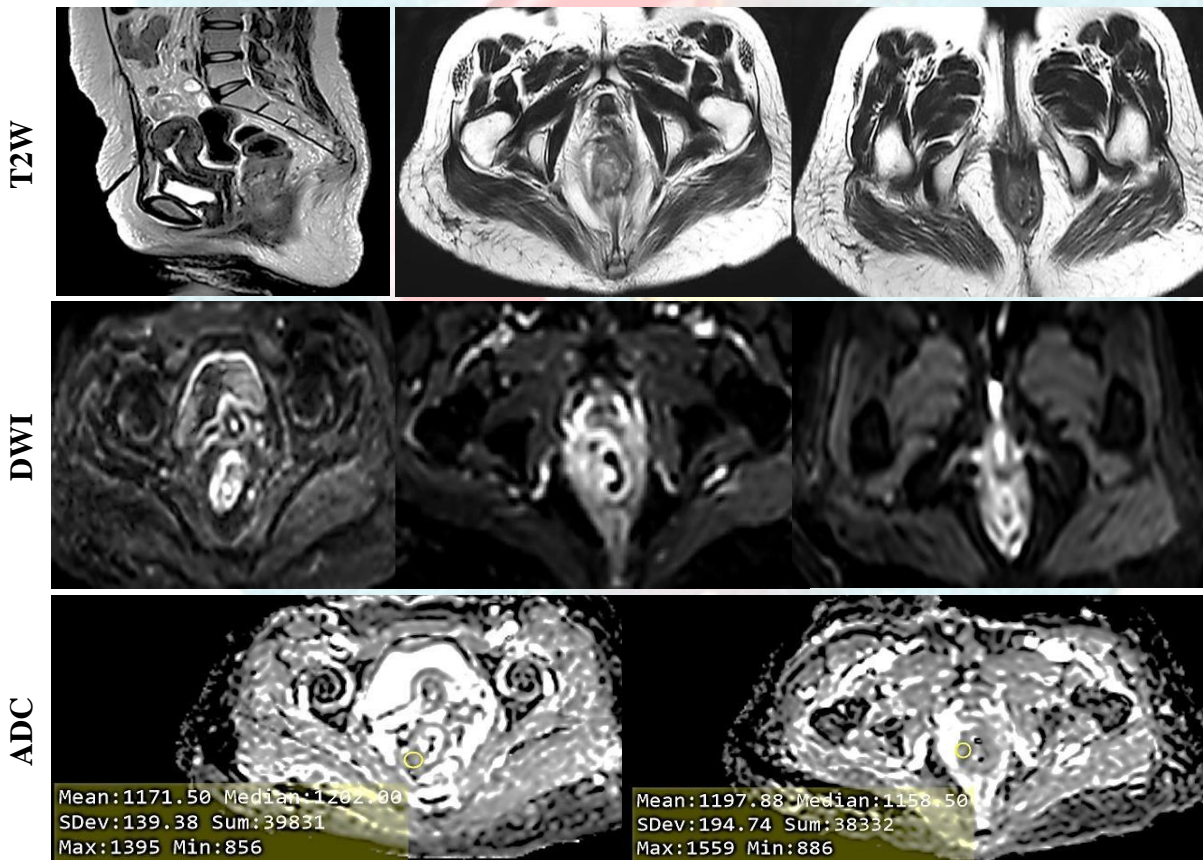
A 52-year old male patient presented with abdominal pain and altered bowel habits. Colonoscopy and biopsy showed moderately-differentiated adenocarcinoma. Pretreatment MRI pelvis
